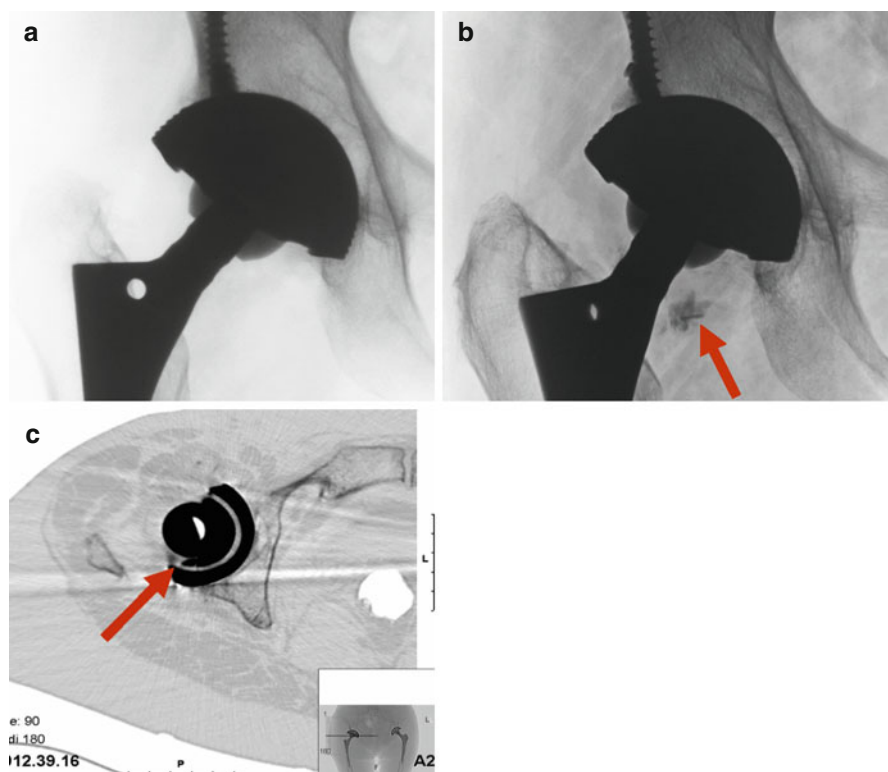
(a) Female, 58 years old, ceramic-on-ceramic coupling with an old sandwich PE liner. (b) Twelve years later, appearance in the X-ray of a new radiological sign suspected for ceramic breakage. (c) CT scan confirms the breakage. The *red arrows* indicate ceramic fragments
